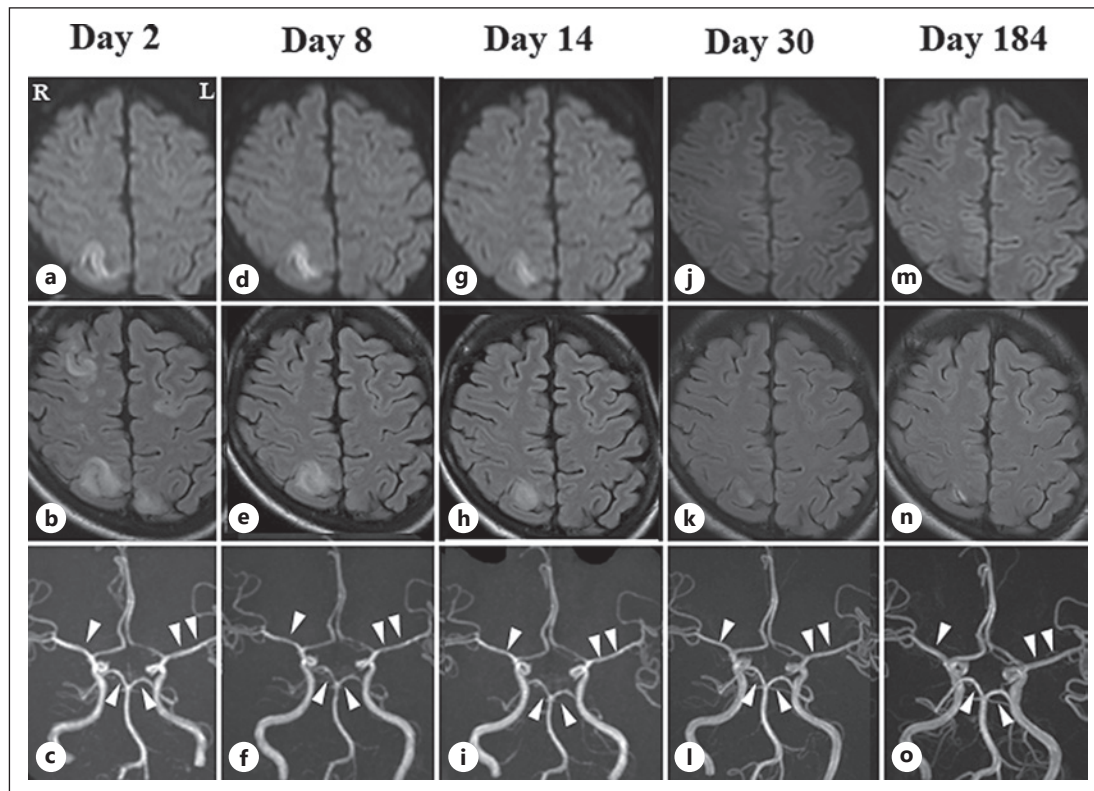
Serial MRI and MRA findings in case 2. MRI on day 2 after onset showing high signal in bilateral frontal and occipital lobes on DWI (a) and FLAIR (b). MRA was normal (c). Brain MRI on day 8 after onset showing a slight reduction of high signal intensity on DWI (d) and FLAIR (e). MRA showing segmental vasoconstriction in the bilateral middle and posterior cerebral arteries (f, arrowheads). Brain MRI on day 14 after onset showing a reduction of high signal intensity on DWI (g) and FLAIR (h). MRA showing slight segmental vasoconstriction in the bilateral middle and posterior cerebral arteries (i, arrowheads). Brain MRI on days 30 and 184 after onset demonstrated a reduction of high signal intensity on DWI (j, m) and FLAIR (k, n). MRA on days 30 and 184 showing complete resolution of the vasoconstriction (l, o, arrowheads).
